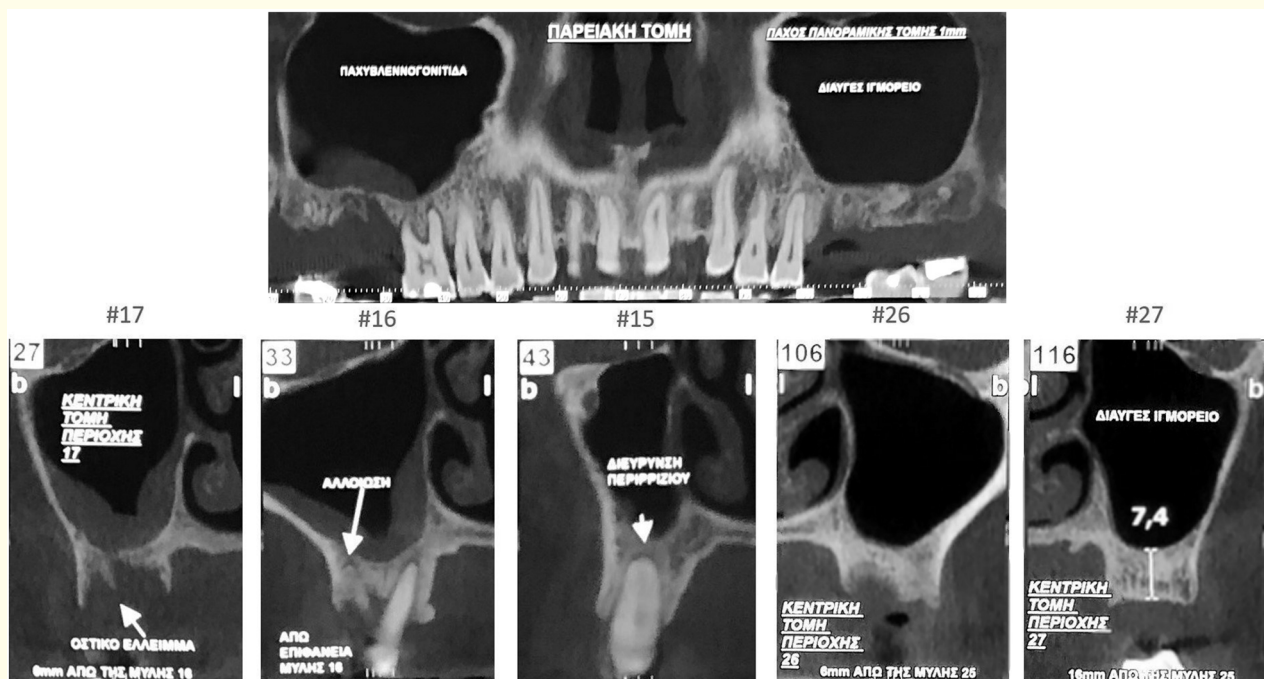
Diagnostic X-ray evaluation before surgery with panoramic view (up) and each single implant position cut (down) of initial CBCT.
